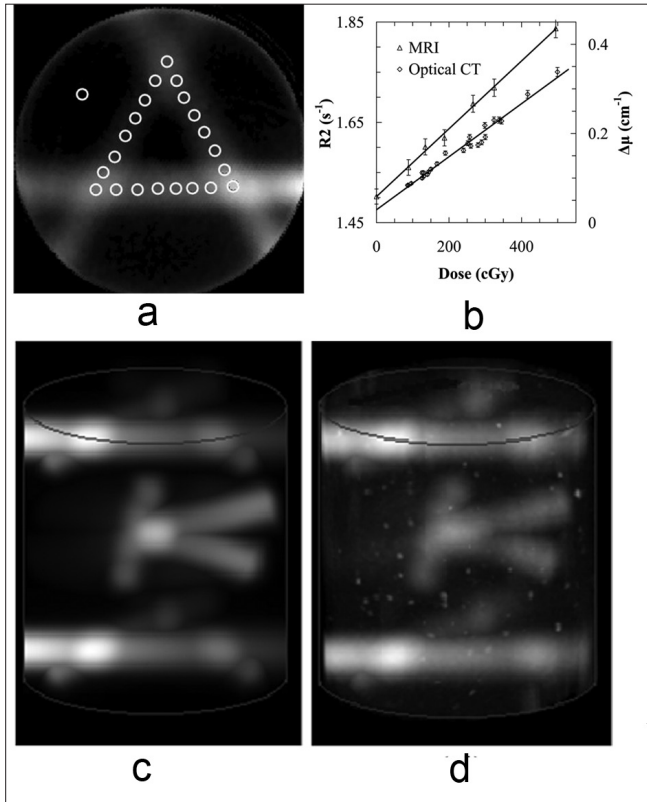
NIPAM gel dosimeters prepared according to procedure A were irradiated using (a) a standard pencil beam “A” pattern. (b) A calibration curve is obtained by registering and correlating well-determined points on the plan and optical CT slice. (c) A volume image of a treatment plan containing two calibration “A” patterns and one measurement “K” pattern, and (d) the corresponding NIPAM gel dosimeter-measured optical CT image.
